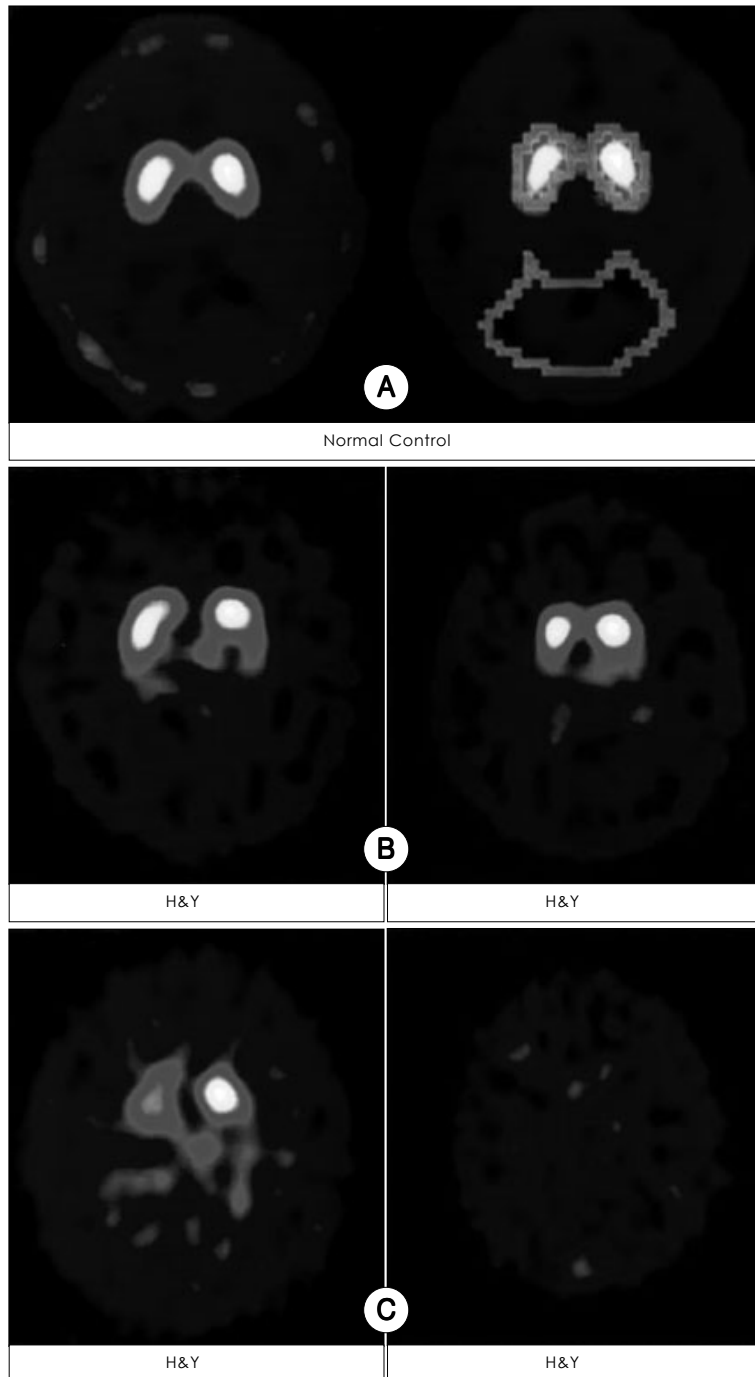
Examples of ^{123}I IPT Brain SPECT. (A) Normal Control. Right : There is symmetrical normal uptake of ^{123}I IPT in bilateral striatum. Left : The RIOs are drawn in bilateral striatum and occipital region for (BG-OCC)/OCC/mCi ratio . (B) Left : Idiopathic Parkinson's disease patient, H-Y classification 1. There is asymmetrically decreased uptake of ^{123}I IPT in left striatum. The decreased uptake is more prominent in putamen than caudate nucleus. Right : Idiopathic Parkinson's disease patient, H-Y classification 2. There is symmetrically decreased uptake of ^{123}I IPT in B basal ganglia. Again, noted is preservation of uptake in bilateral caudate nucleus. (C) Left : Idiopathic Parkinson's disease patient, H-Y classification 3. Decreased uptake of radiotracer in bilateral basal ganglia is much more prominent than C. The decreased uptake of radiotracer in R caudate nucleus is obvious. Right : Idiopathic Parkinson's disease patient, H-Y classification 4. There is no visible uptake of ^{123}I IPT in B basal ganglia.
